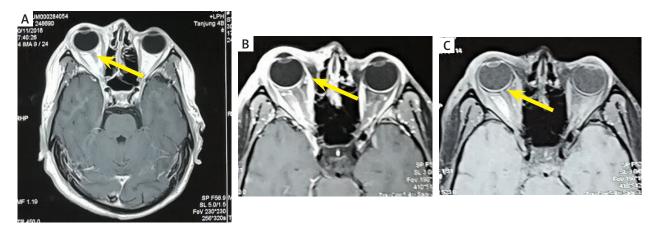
A-B) T1-weighted axial brain/ orbit MRI showing an enhancement on the rectus muscle of right eye (arrow). C) T1-weighted orbit MRI revealing right perineural enhancement (arrow)
